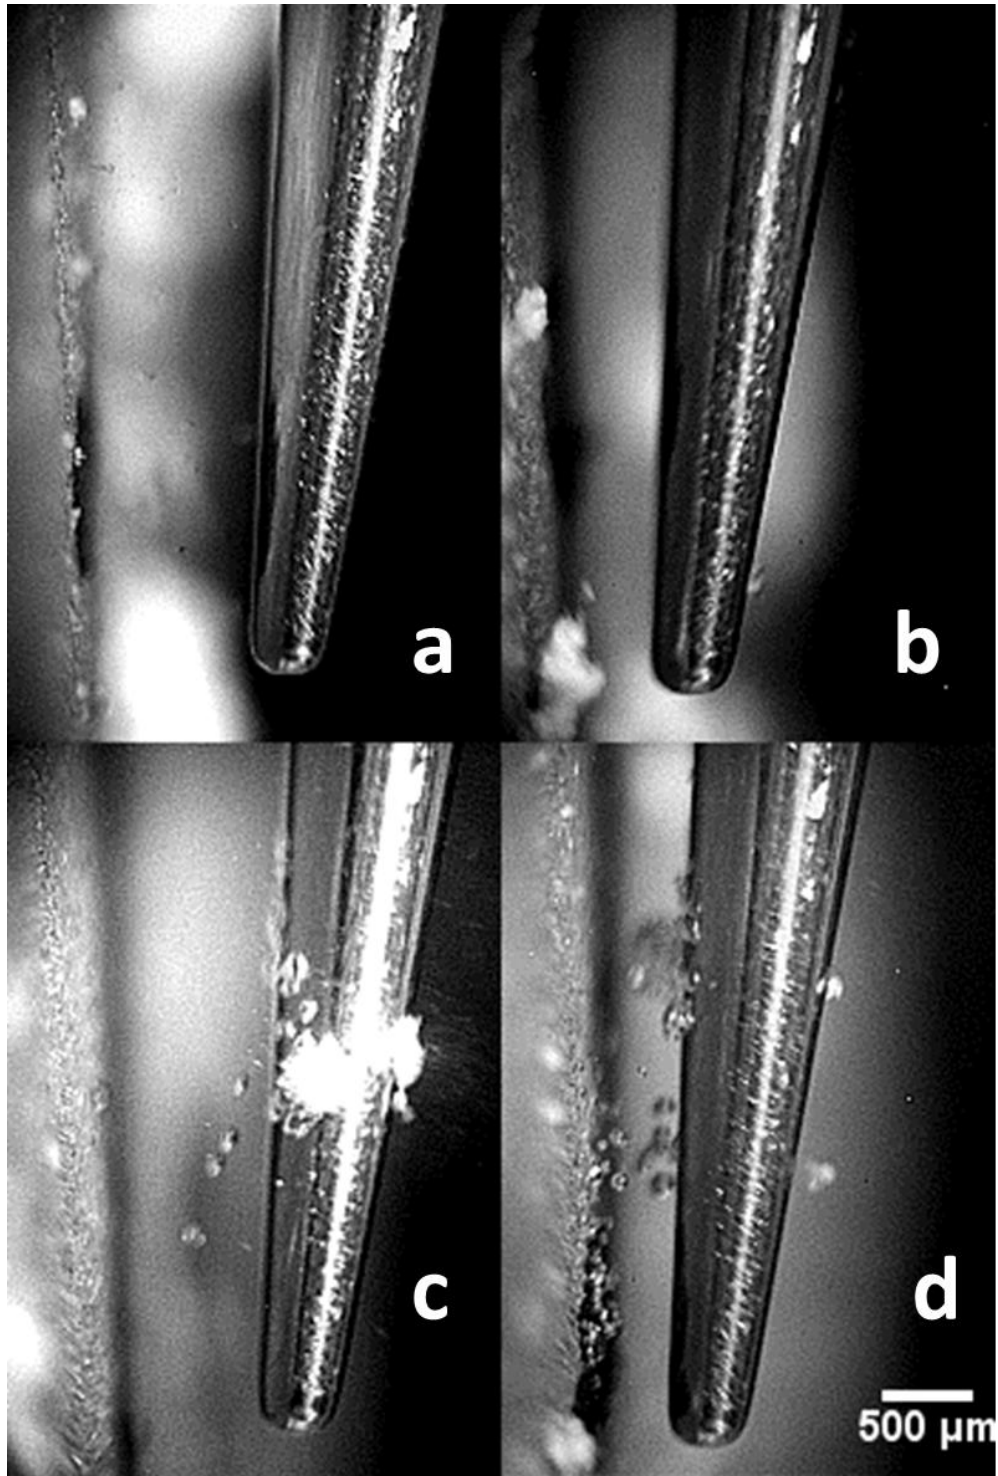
High speed image stills of the ultrasonic scaler tip next to the sample during biofilm removal. (a) power 5, 1 mm away from disc. (b) power 5, 0.5 mm away from disc. (c) power 10, 1 mm away from disc. (d) power 10, 0.5 mm away from disc.
